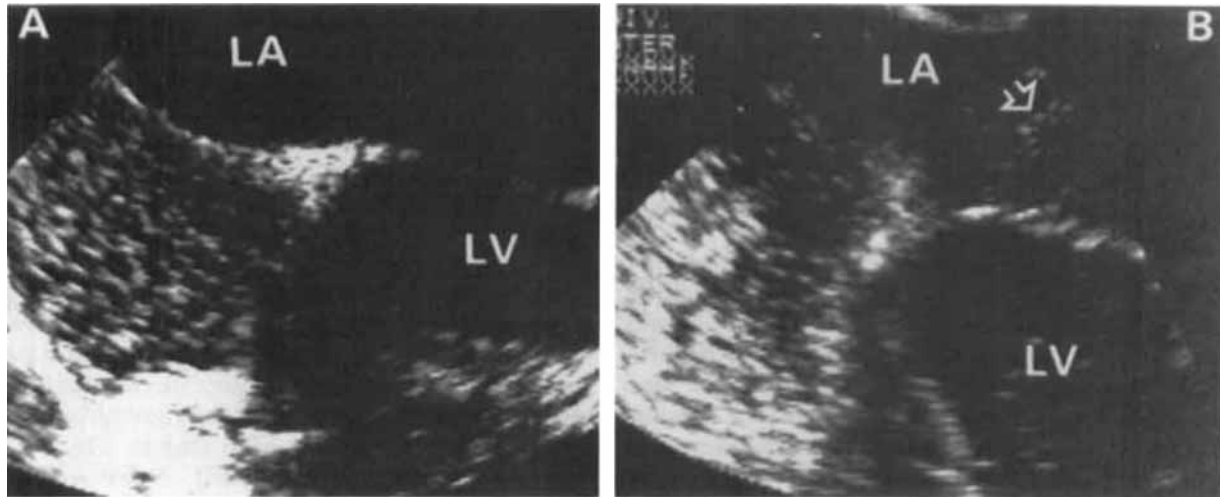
Transesophageal echocardiogram of a patient (A) during intermittent positive pressure ventilation and (B) during the application of 10 cm of positive end-expiratory pressure. Arrow, targets in the left atrium (LA) denoting interatrial shunting; LV, left ventricle. Unlabeled chambers in the lower left corner filled with echo targets are the right atrium and right ventricle.
